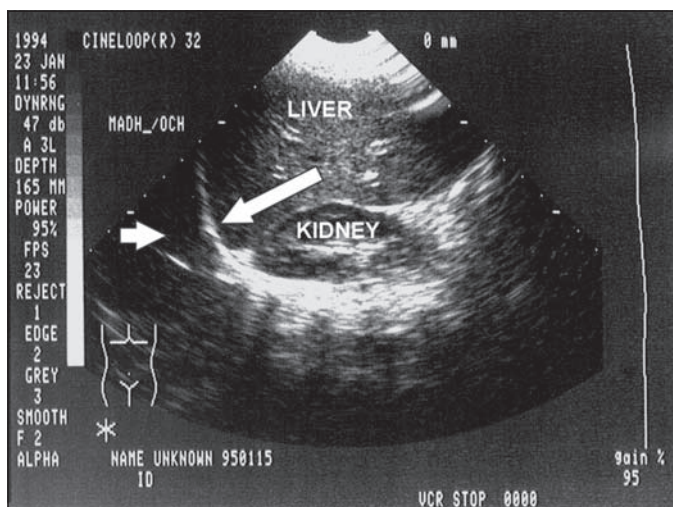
Ultrasonic view of the right supradiaphragmatic space. The short arrow depicts the inferior aspect of the lung while the long arrow demonstrates the hyperechoic diaphragm.
